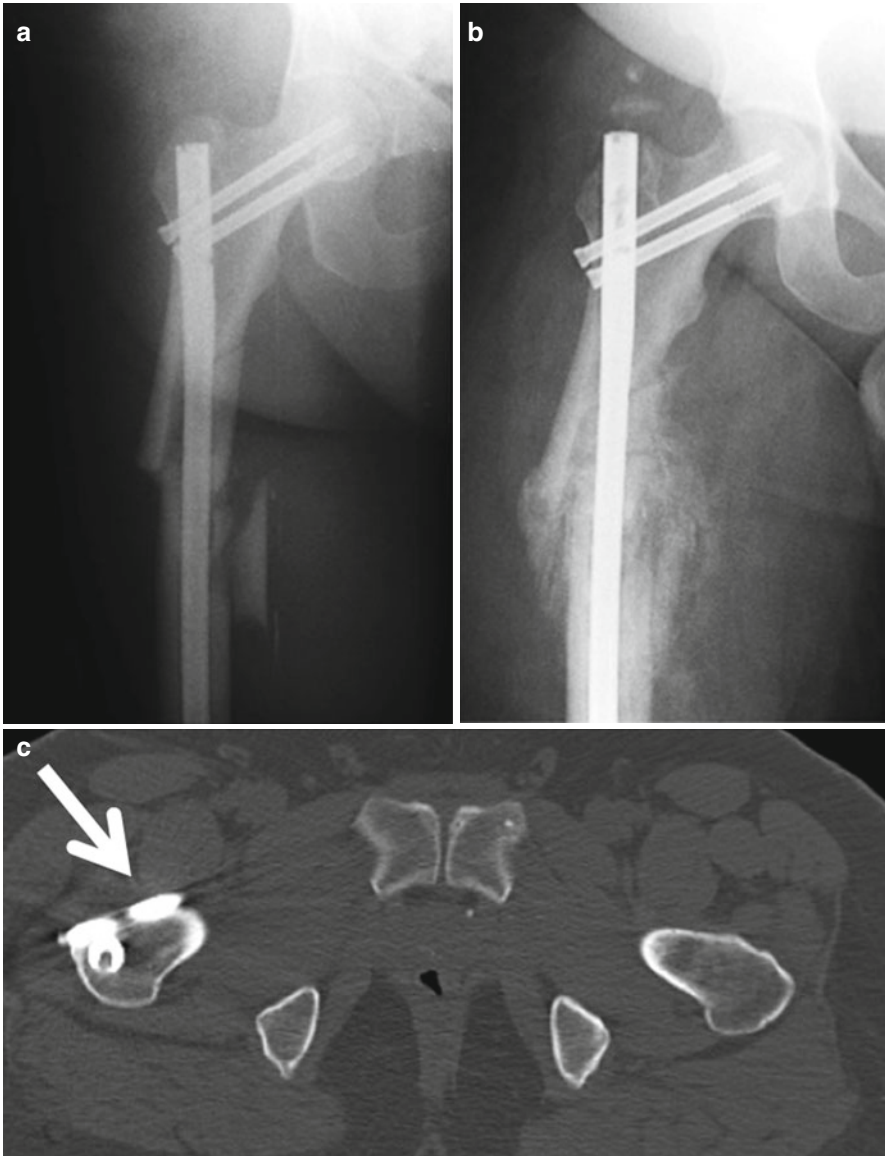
This morbidly obese man sustained a femoral shaft fracture as a result of a motor vehicle accident. He was treated by intramedullary nailing using a cephalomedullary reconstruction nail. Immediate postoperative radiograph shows acceptable fracture reduction in slight varus position (a). Radiographs taken at 8 weeks post-operatively show fracture shortening and increased varus angulation (b). Not visualized is a clinical increase in rotational deformity. Note the changed position of the two interlocking screws with respect to the proximal end of the nail compared to the immediate post-operative position. Neither screw was correctly placed through the holes in the intramedullary nail leading to fracture shortening, angulation, and malrotation that required additional corrective surgery. Computed tomography scan (c) showing the interlocking screw anterior to rather than through the intramedullary nail (*arrow*)
